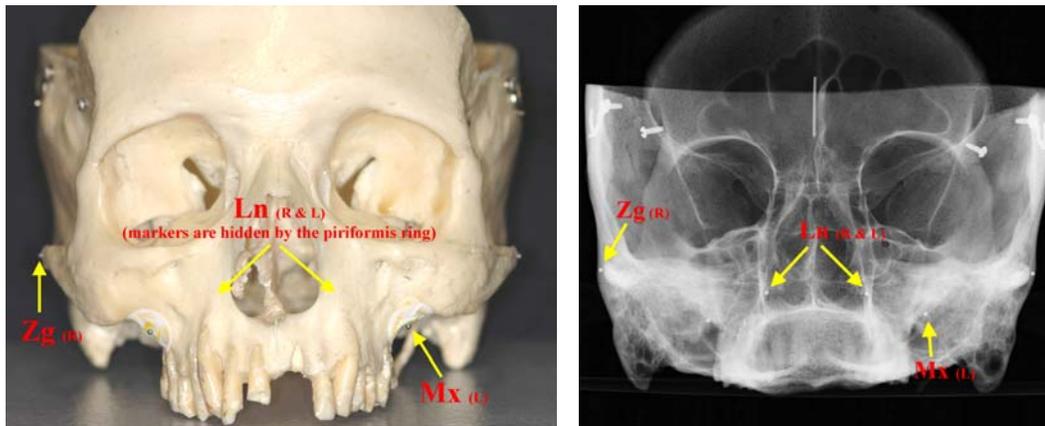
Left:* Dry skull with metallic markers on landmarks of interest / *Right:* Radiographic image of same dry skull and markers
